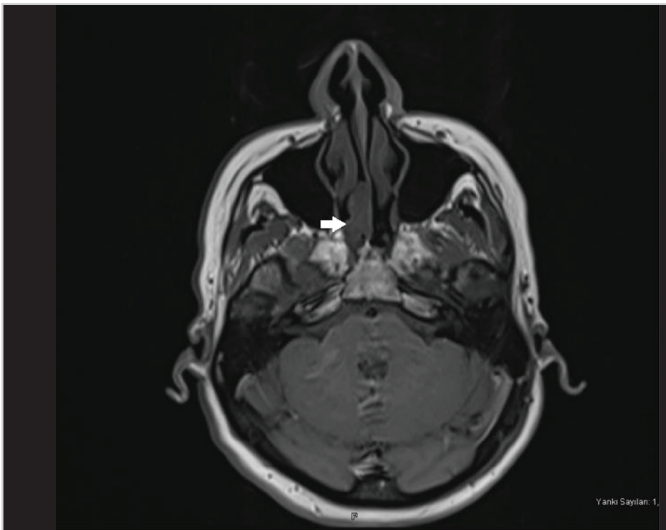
a. A hypointense lesion was observed in the right nasal cavity on T1-weighted sequences of MRI
